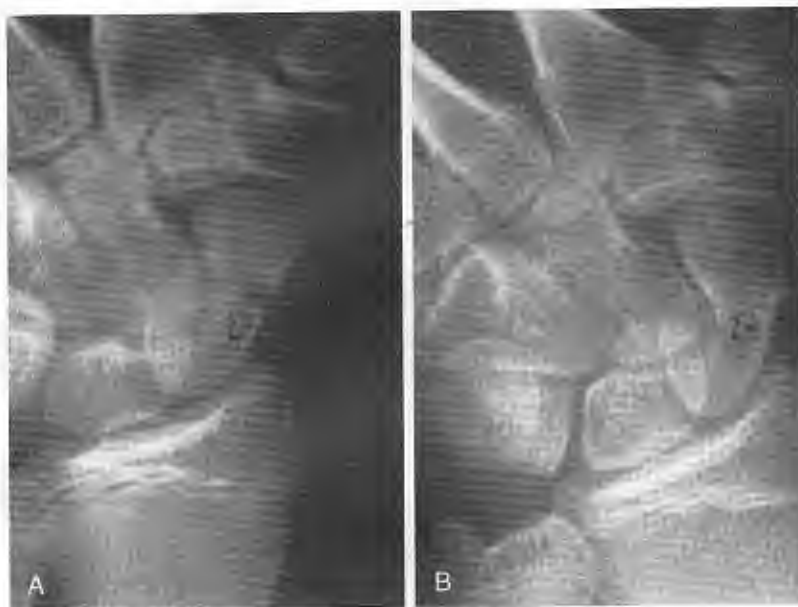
Football athlete who was injured during the season complained of some wrist pain for several months. During winter workouts he was evaluated clinically and radiographically and a scaphoid fracture is shown in the skeletally immature patient. *A*, The left wrist with open growth plates shows a mid-waist of scaphoid fracture without displacement (*arrow*). *B*, Treatment in a long arm cast for 4 weeks and short arm cast for 6 weeks revealed radiographic and clinical union (*arrow*).
